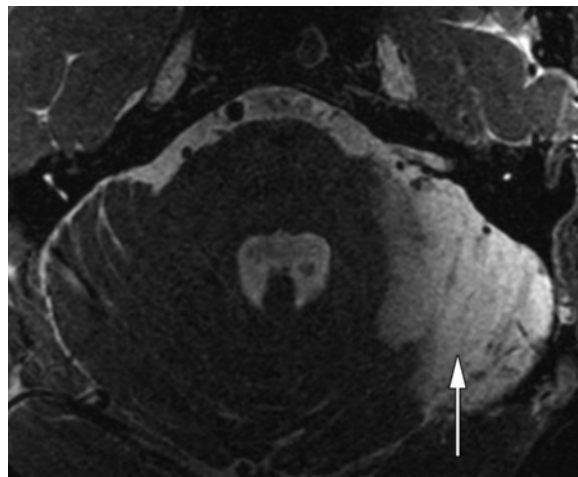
Cerebellar atrophy. Axial spin-echo T2-weighted MR image obtained following suboccipital resection of a schwannoma shows typical atrophy of the right cerebellar hemisphere (arrow) as a result of retraction.
